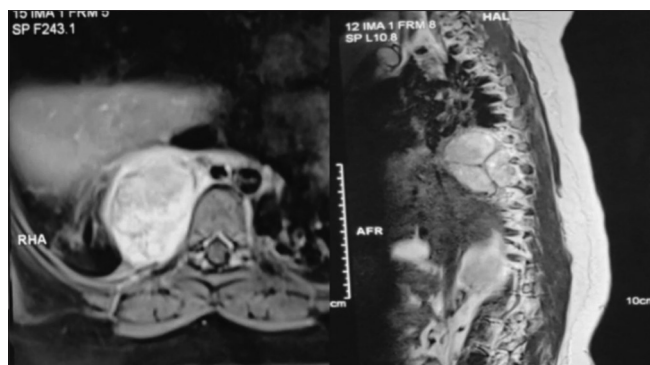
MRI of the spine showing the right-sided paraspinal supradiaphragmatic mass. MRI: Magnetic resonance imaging
